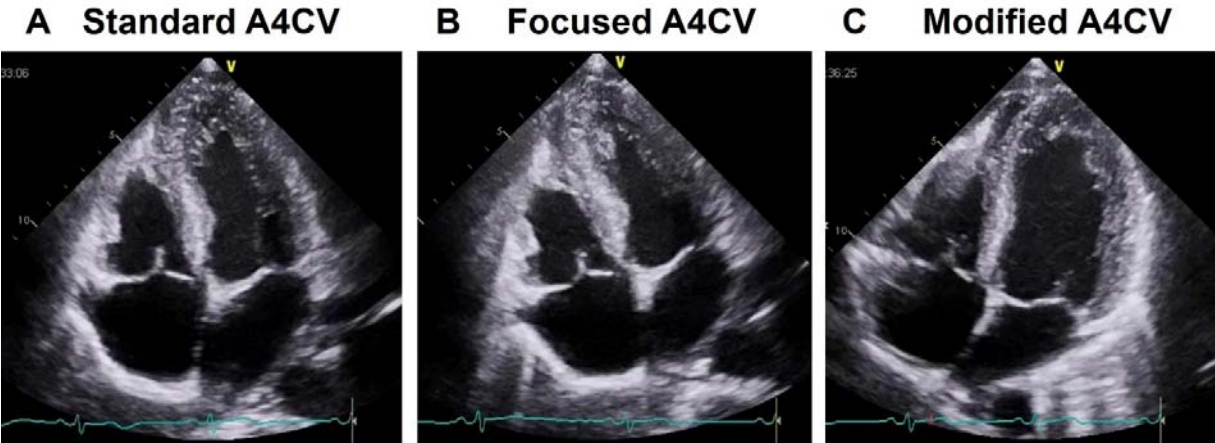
Apical four-chamber views used to perform comprehensive evaluation of the right heart.
